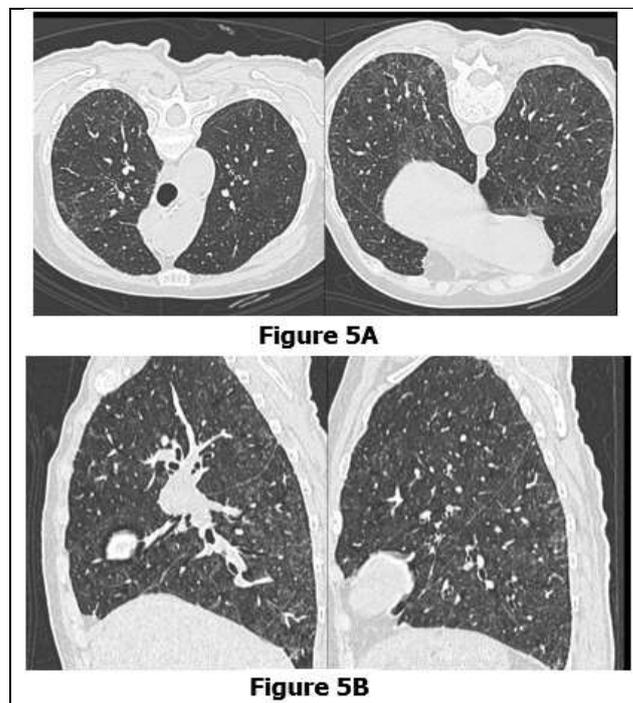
The axial (A) HRCT lung images show ill-defined intralobular interstitial and septal thickening with peripheral distribution and lower zone predominance in the lung parenchyma bilaterally. The sagittal reconstructed (B) images shows apico-basal gradient with subpleural sparing.
